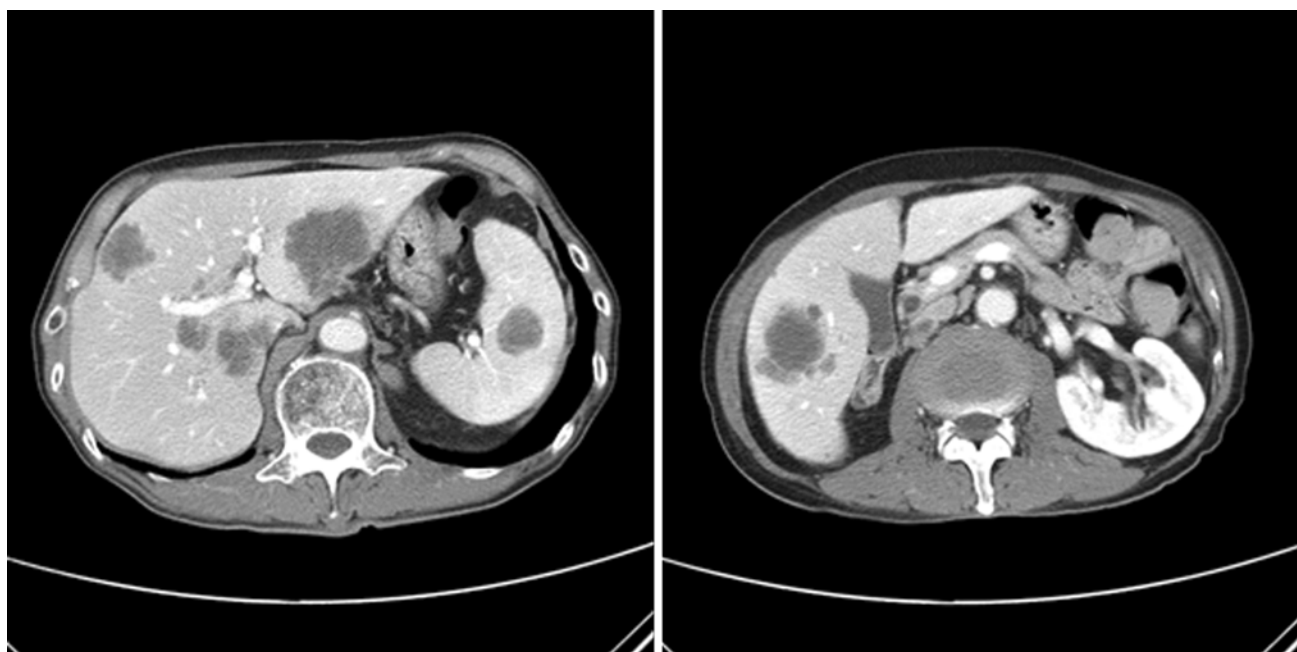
Postoperative 5 months follow-up CT scan showed multiple metastases in the liver and spleen and metastatic lymphadenopathy in aortocaval and retrocaval space
